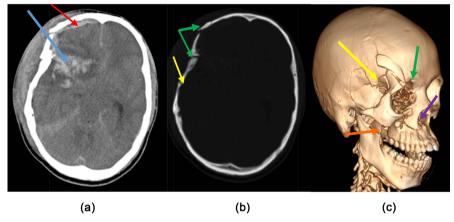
Kira Hospital; 27-year-old patient: Cranioencephalic computed tomography: axial slice through the parenchymal window (a): right frontotemporal cortico-subcortical parenchymal contusion with peripheral oedema (blue arrow) and an ipsilateral frontal subdural hematoma blade (red arrow) accompanied by a mass effect on the median structure. Bone window (b) and 3D reconstruction (c): right plurilocular fractures: frontal fracture affecting the roof of the orbital (green arrow); fracture of the jawbone extended to the orbital floor (purple arrow), sphenoidotemporal fracture (yellow arrow) and fracture of the base of the coronoid process of the mandible (orange arrow).
